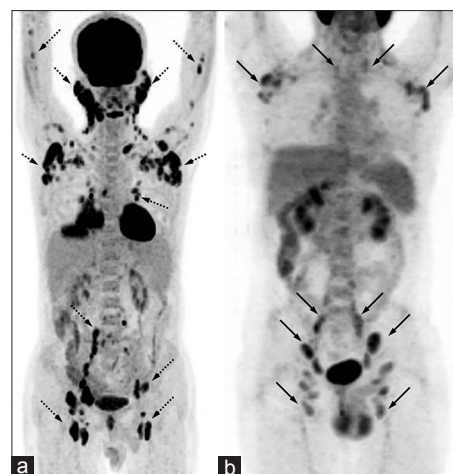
(a and b) A 57-year-old male with CD3+ peripheral T-cell lymphoma. Maximum intensity projection (MIP) positron emission tomography (PET) image (a) revealing ^{18}F -2-fluoro-2-deoxy-glucose (^{18}F -FDG) avid bilateral multiple cervical, axillary, mediastinal, abdomino-pelvic and inguinal lymph nodes (broken arrows), 27-year-old male with angiolymphoblastic T-cell lymphoma. MIP PET image (b) revealing mild to moderately ^{18}F -FDG avid bilateral multiple cervical, axillary, mediastinal, abdomino-pelvic and inguinal lymph nodes (arrows)
